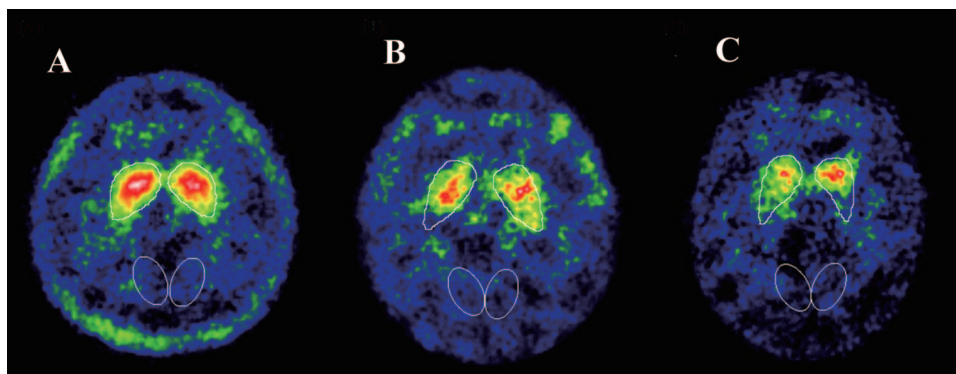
Tc-99m TRODAT SPECT of healthy nonsmoker (grade I) (A), current smoker with less than 1 pack smoked per day (grade II) (B), and current smokers with equal or more than 1 pack smoked per day (grade III) (C).
